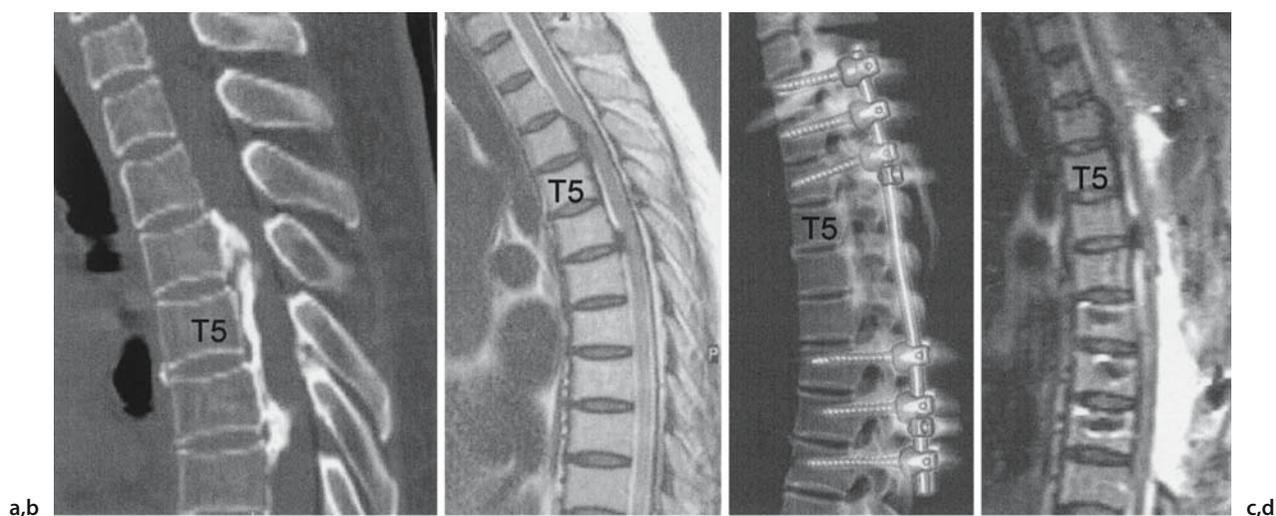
Indirect decompression is accomplished by correcting thoracic kyphosis. Preoperative and postoperative CT and MRI of a 58-year-old woman with OPLL between T4 and T7.
